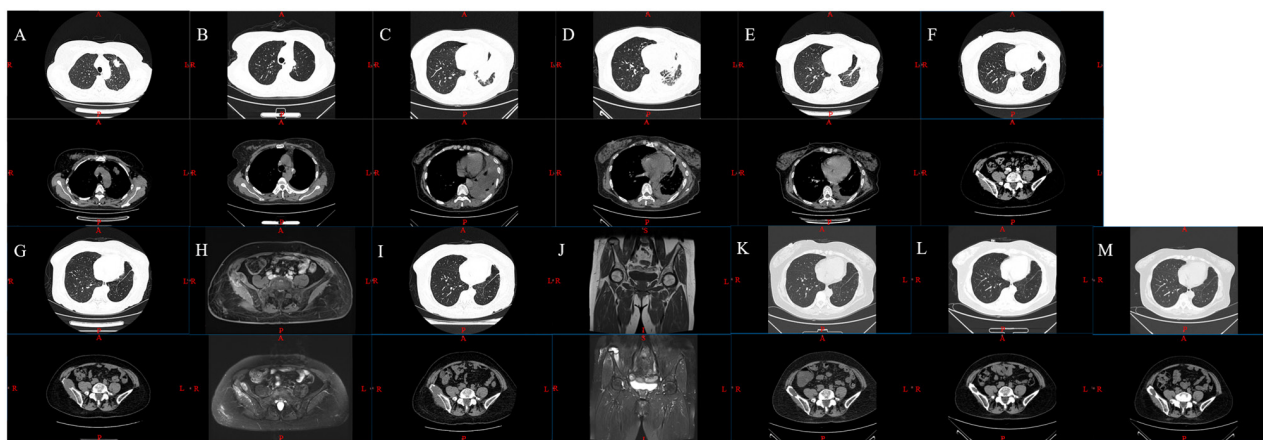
CT and MRI scans images. CT scans on (A) 2017-09, (B) 2017-10, (C) 2019-01, (D) 2019-03, (E) 2019-06, (F) 2019-11 and (G) 2020-02. MRI scan on (H) 2020-02, CT scan on (I) 2020-06, MRI scan on (J) 2020-08, and CT scans on (K) 2022-11, (L) 2023-03 and (M) 2023-07. CT, computed tomography; R, right; L, left; A, anterior; P, posterior; S, superjacent; I, inferior.
